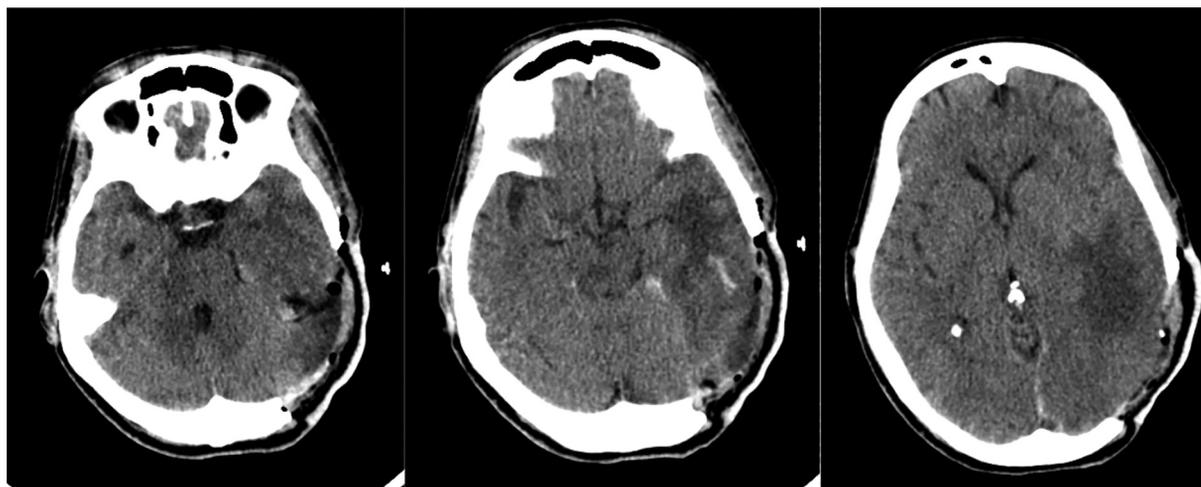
Postoperative computed tomography showing an excellent tumor resection, but the patient presented with a left temporal edema and intraparenchymatous hematoma in the territory of the Labbé drainage secondary to vein infarction.
